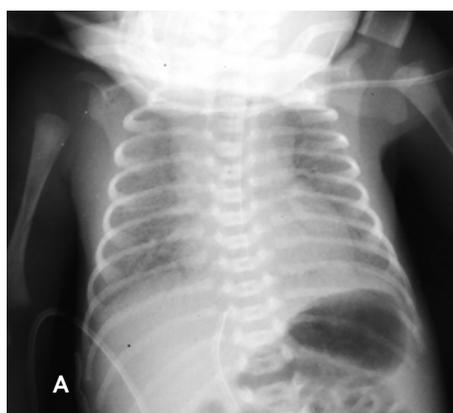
Twin A: A) Chest X-ray following stabilization with bubble CPAP on day of life 1 showing signs of hyaline membrane disease; B) Chest X-ray following acute deterioration on day of life 2 revealing accumulation of air inside the pericardial sac (pneumopericardium).
